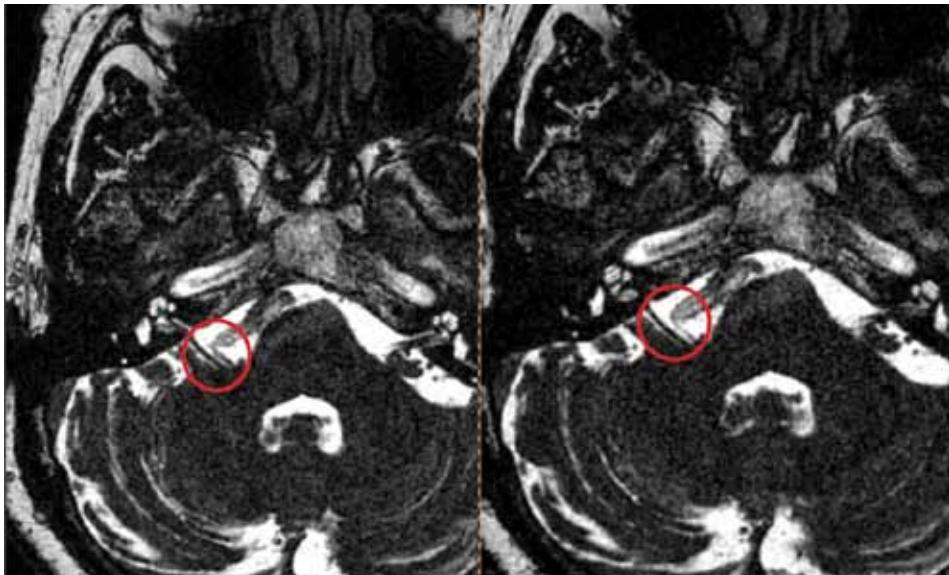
MRI using FISP MRA sequence revealed a neurovascular conflict caused by the cross-passing loop of the right VA imposing the right facial nerve
